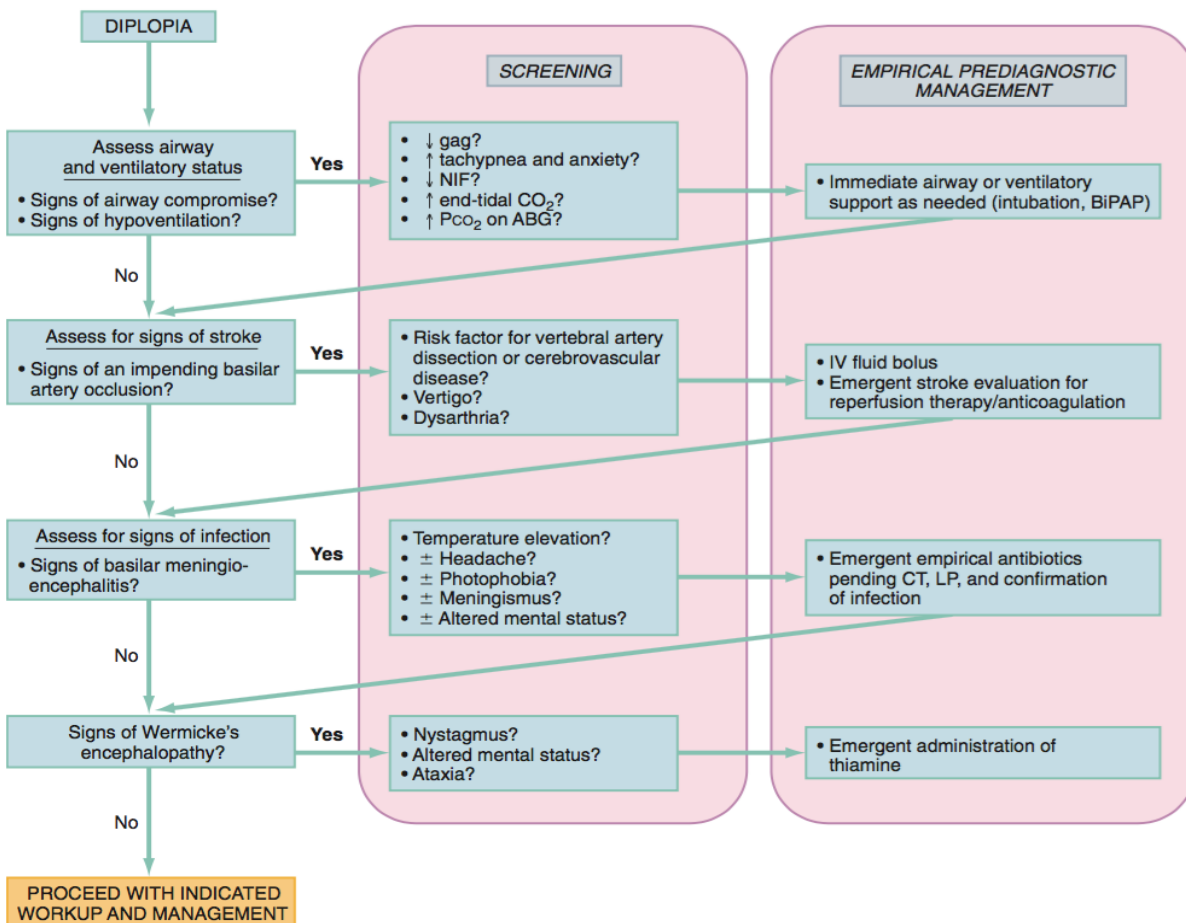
Algorithm for the initial stabilization of the patient with diplopia in the emergency department—a guideline. *ABG*, arterial blood gas; *BiPAP*, biphasic positive airway pressure; *CO₂*, carbon dioxide; *CT*, computed tomography (of the cranium); *IV*, intravenous; *LP*, lumbar puncture; *NIF*, negative inspiratory force; *Pco₂*, partial pressure of carbon dioxide.
